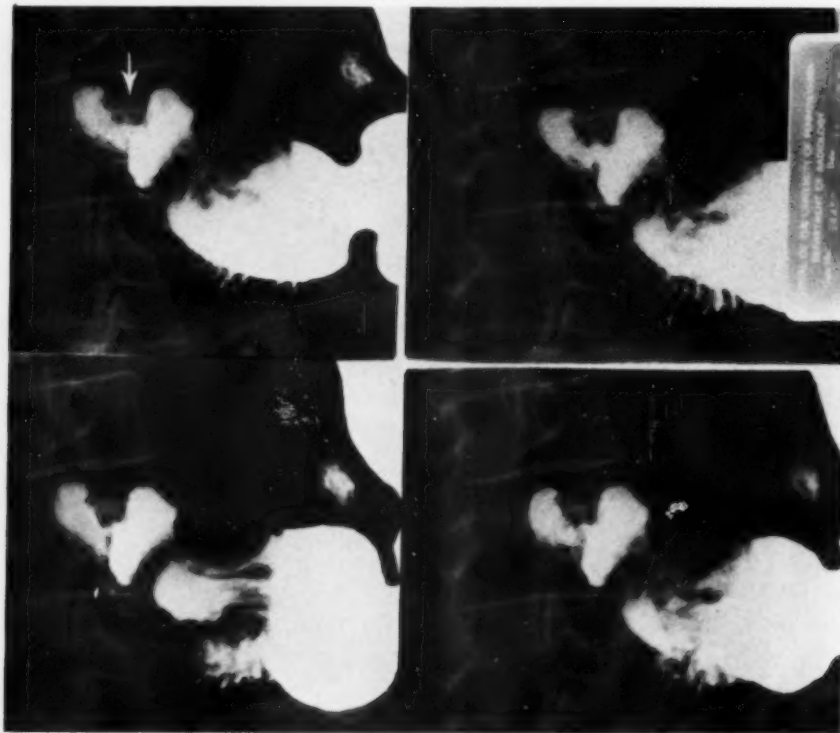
Carcinoma of the head of the pancreas. Patient 72 years of age complained of pain in the epigastrium, radiating into the right subcostal region and right shoulder, for one year. During this time she had lost 40 lb. in weight. Her stools were clay-colored and urine dark. Cholecystography revealed an abnormal functioning gallbladder. At operation the gallbladder was distended and the common duct dilated as a result of a large carcinoma in the head of the pancreas. The serial roentgenograms reveal a defect in the cap (indicated by the arrow) which was misinterpreted as a duodenal ulcer rather than the "duodenal impression" it actually proved to be. The roentgenograms were made in the prone right anterior oblique position.
